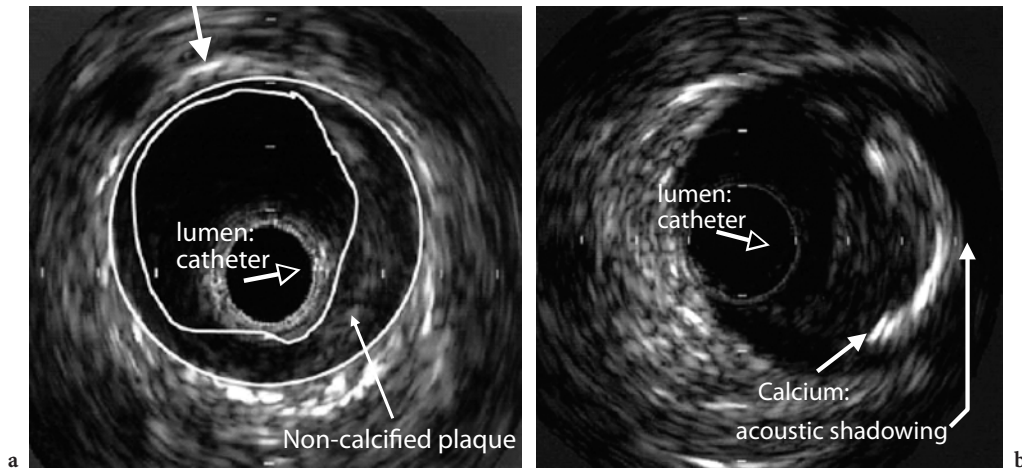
Cross-sectional intravascular ultrasound (IVUS) images of a left coronary artery showing non-calcified atherosclerotic wall change (a) and a calcified plaque causing elimination of the ultrasound signal (b). (Images courtesy of Klinikum Grosshadern, Munich, Germany)
